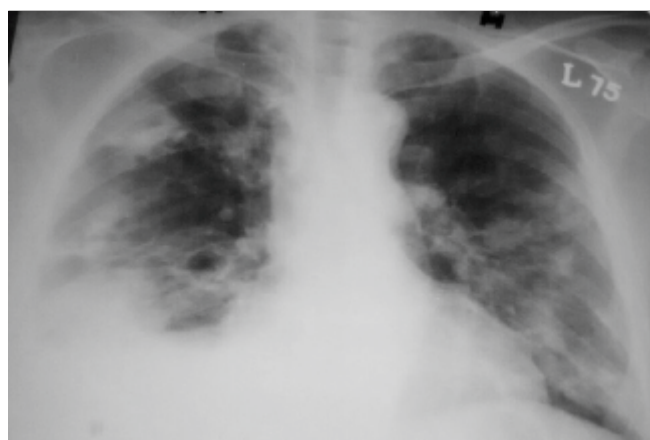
Plain X-ray P-A view shows bilateral ill-defined cavitating nodules and homogenous opacity in right lower zone with obliteration of the right costophrenic angle
